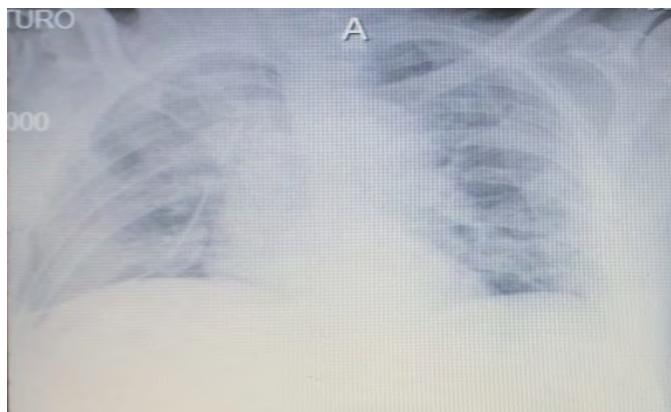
Plain chest radiograph: RALE 7-point bilateral interstitial socket pattern.
